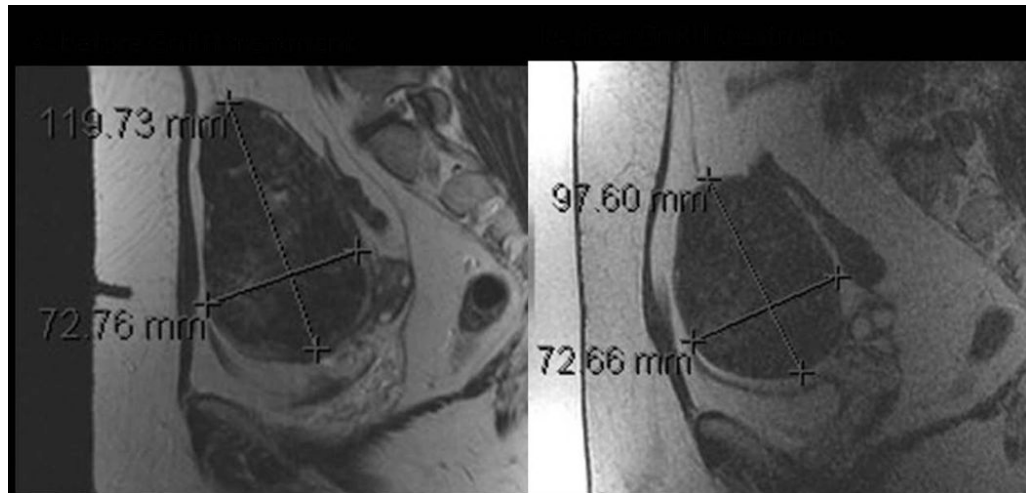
MR imaging of GnRH agonist effect. T2 weighted imaging of a large uterine fibroid, before (A) and three months after (B) treatment with GnRH agonist. The size of the fibroid is decreased, and the signal intensity has become homogeneously low after management.
